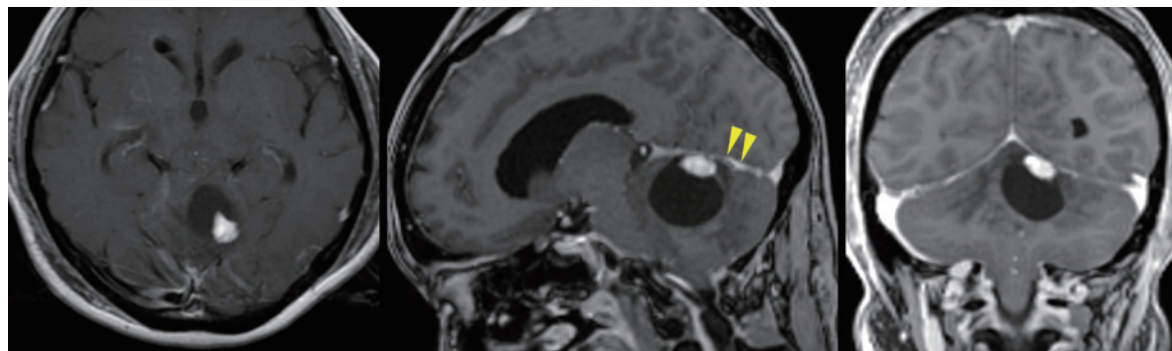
Preoperative T1-weighted gadolinium-enhanced image of the mass lesion surrounded by a cyst. The draining vessel is present at the tentorial surface of the cerebellum (arrowhead).
